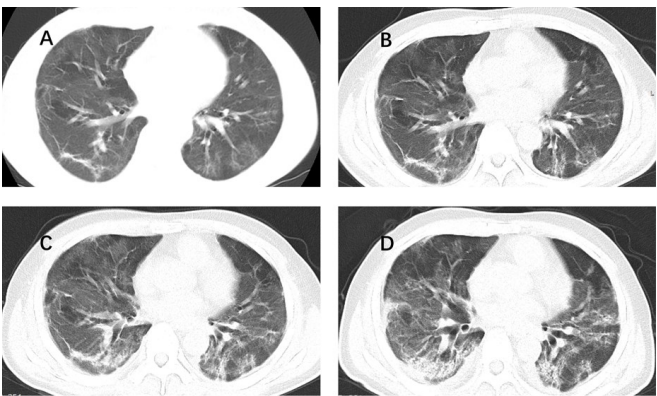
Chest CT images from a 47-year male. (A) Day 34 after symptom onset: Bilateral diffuse ground-glass opacities and consolidations, with air bronchograms inside (red arrow) with local thickening and adhesions of bilateral pleura; (B) Day 46: the lesions had decreased in extent and the density; (C) Day 53: the lesions continued to decrease in extent and the density; (D) Day 61: the lesions continued to decrease in extent and the density. The patient was ready for discharge from hospital after the final scan.
